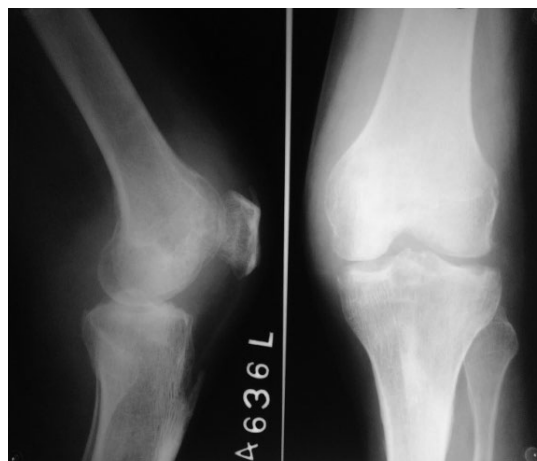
X-ray left knee joint. After treatment.
